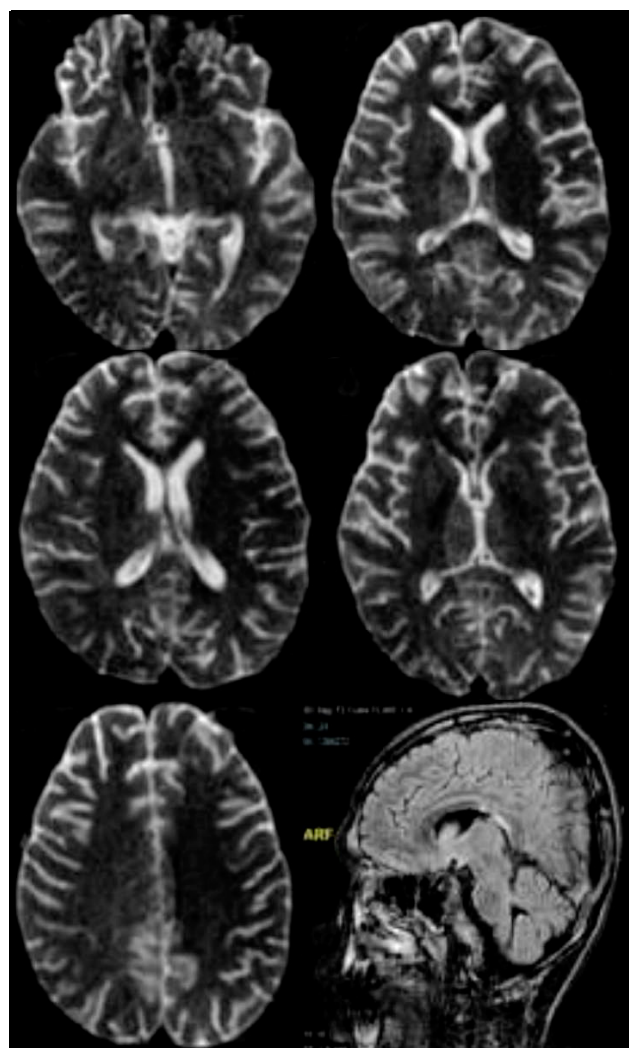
Diffusion tensor imaging (DTI) showed no abnormalities, however, T2-weighted sagittal FLAIR showed similar hyperintensity at body of corpus callosum.
